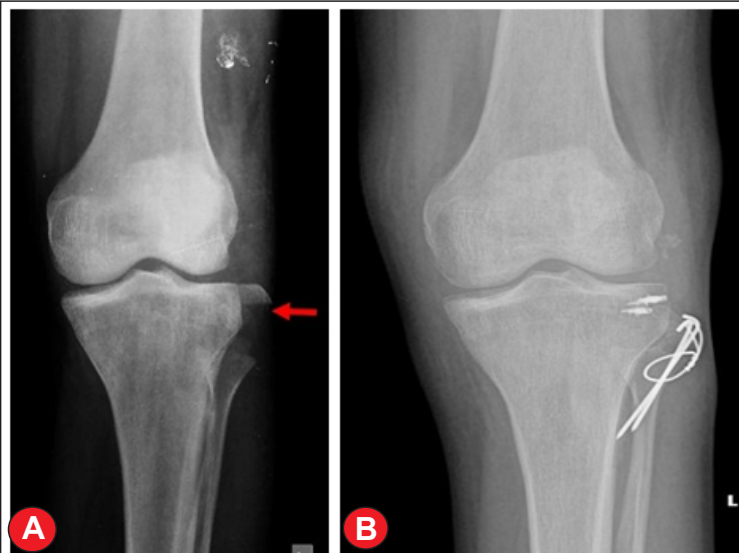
(a) Radiograph is showing avulsion fracture of the fibular head (arcuate sign - Arrow). (b) Post-operative X-ray show the tension band wiring and repair with suture anchors.
